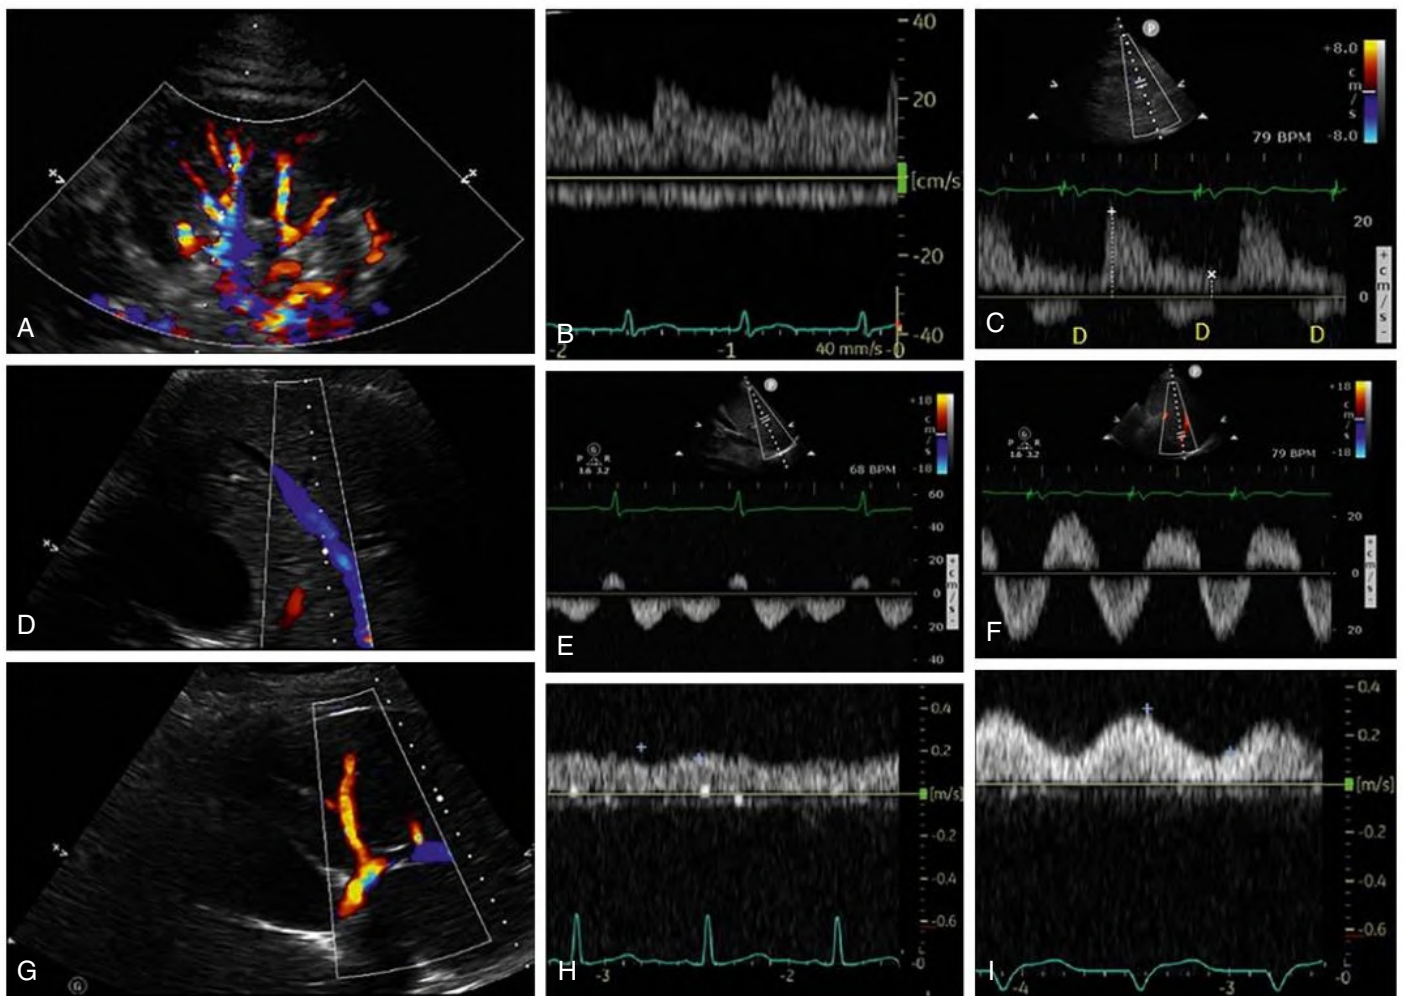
Examples of Normal and Abnormal Venous Doppler Waveforms. (A) Color Doppler image showing the site of intrarenal Doppler assessment. (B) Normal intrarenal Doppler showing a normal arterial resistive index (above the baseline) and a continuous venous signal during the cardiac cycle (below the baseline). (C) Abnormal intrarenal Doppler showing both a high resistive index and discontinued venous signal only present in diastole (indicated by letter *D*). (D) Color Doppler image showing the right hepatic vein. (E) Normal hepatic vein Doppler with dominant systolic component. (F) Abnormal hepatic vein flow with reverse systolic component and only *D*-wave below the baseline. (G) Color Doppler image showing the main portal vein. (H) Normal portal vein Doppler showing minimal (<30%) variation in velocities during the cardiac cycle. (I) Abnormal portal vein Doppler with pulsatility (≥50% variation) during the cardiac cycle.
